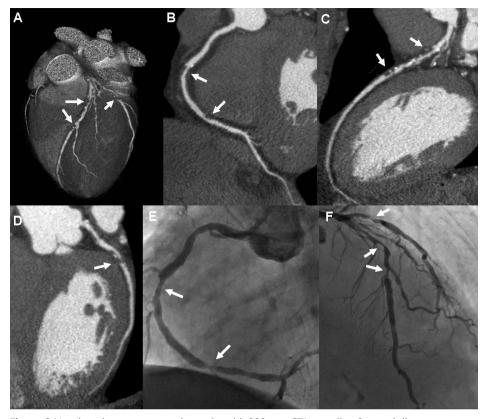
Non-invasive coronary angiography using 320-row CTA revealing the absence of significant CAD.
